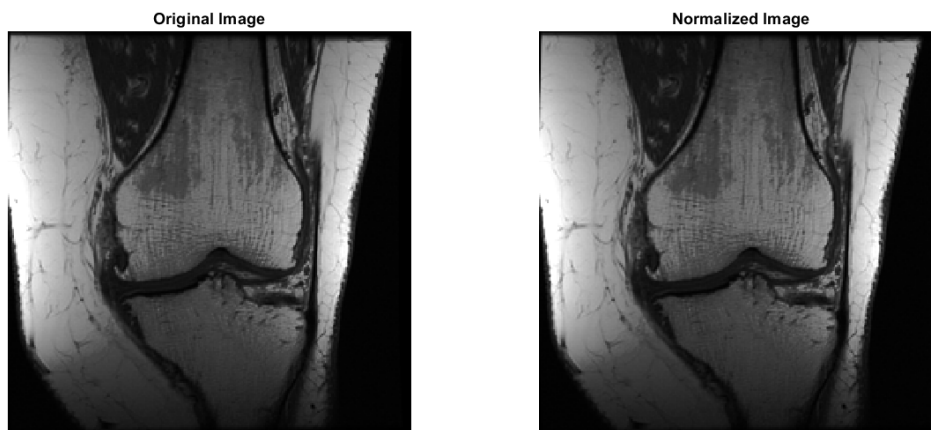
Normalization process done into a coronal PD MRI. [33]
